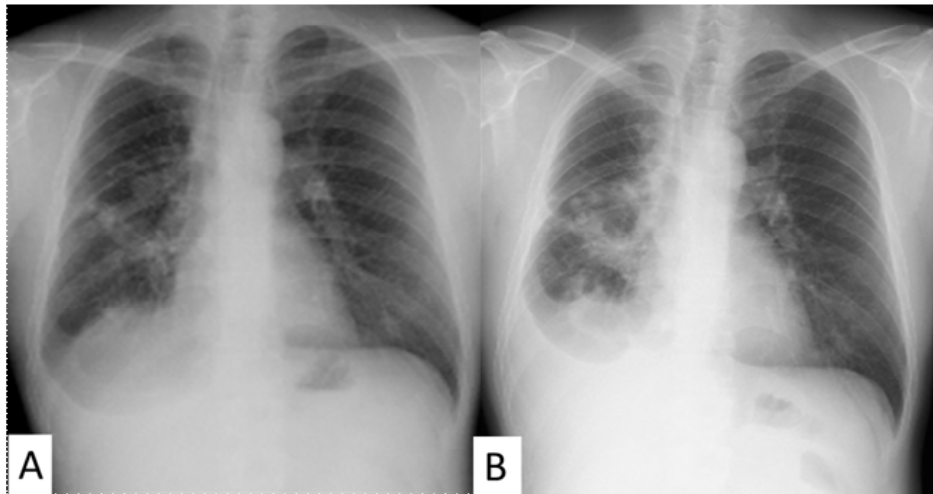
(A) The chest radiograph obtained a year ago showing multiple nodules in the right lung with pleural effusion. (B) The chest radiograph obtained at first visit showing progression of the lesions but not rapidly.
